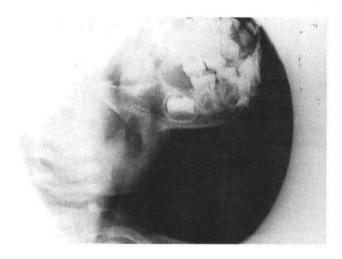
Lateral oblique radiograph of the right mandible before injection of contract media showing soft tissue swelling in the region of the right parotid gland. There is no calculus in the duct or gland parenchyma.
